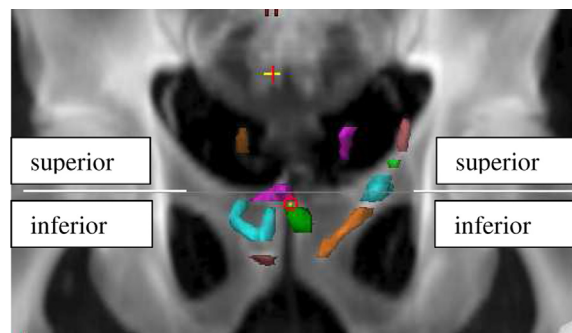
Coronal view of a prostate bed, separated into superior and inferior portions along the superior border of the pubic bone. Also shown are segments of the surgical clips that are identified as trackable through all cone beam computed tomography sets. The position of each clip is represented by its center of mass.
